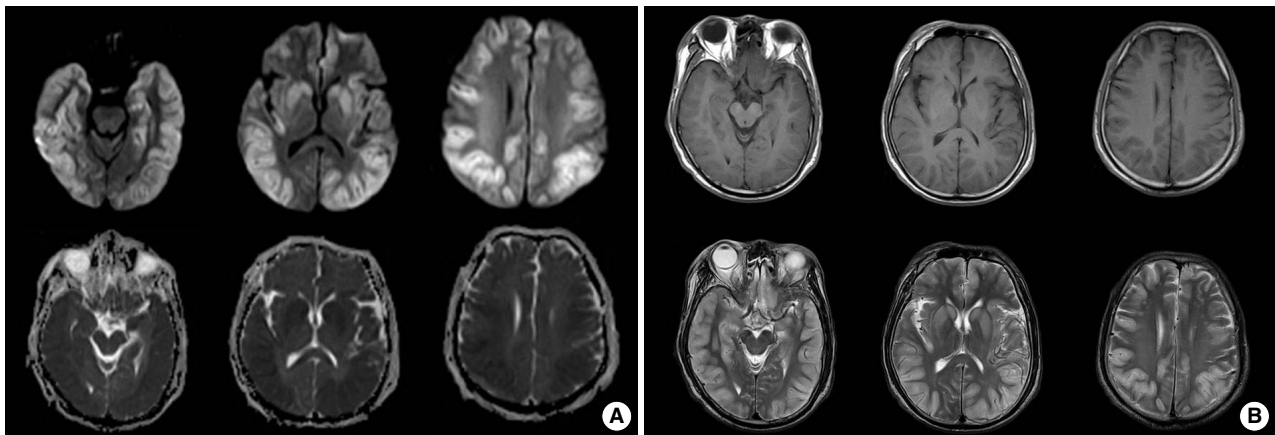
The initial magnetic resonance imaging. (A) Diffusion-Weighted MRI of the brain showed multiple bilateral hyperintense signals along the cortical and subcortical regions (frontal, temporal, parietal, and occipital lobes), hippocampus, caudate, globus pallidus, and putamen and ADC (apparent diffusion coefficient) map showed low signal at the same area. (B) Low signal intensity lesion at T1-weighted image and High signal intensity lesion at T2 weighted image were seen at same area (Fig. 1B).
